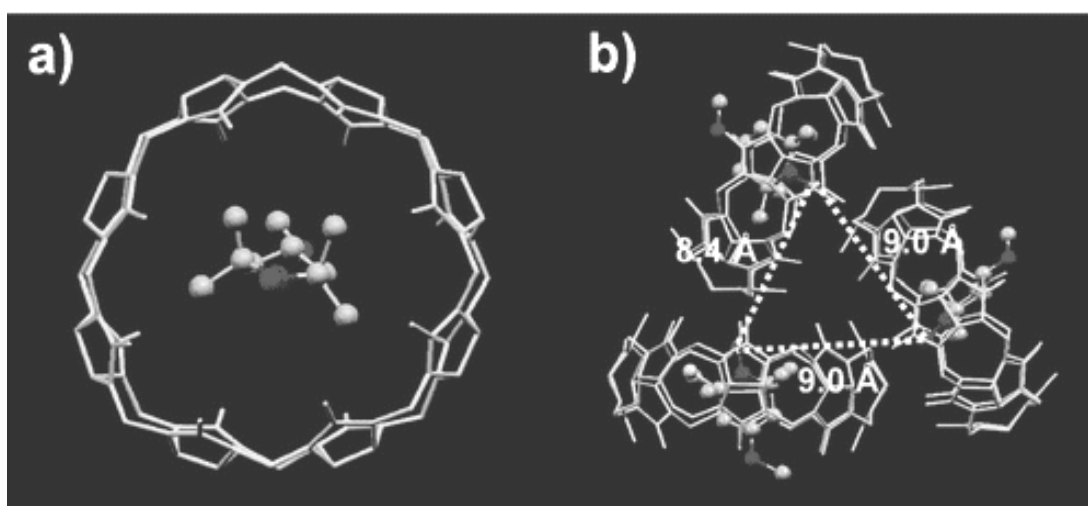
a) X-ray structure of the 14@CB8 inclusion complex; b) supramolecular triangle showing a three-spin-system interaction in the solid state. Reproduced from *J. Am. Chem. Soc.*, 2009, 131, 5402, with permission of American Chemical Society.
